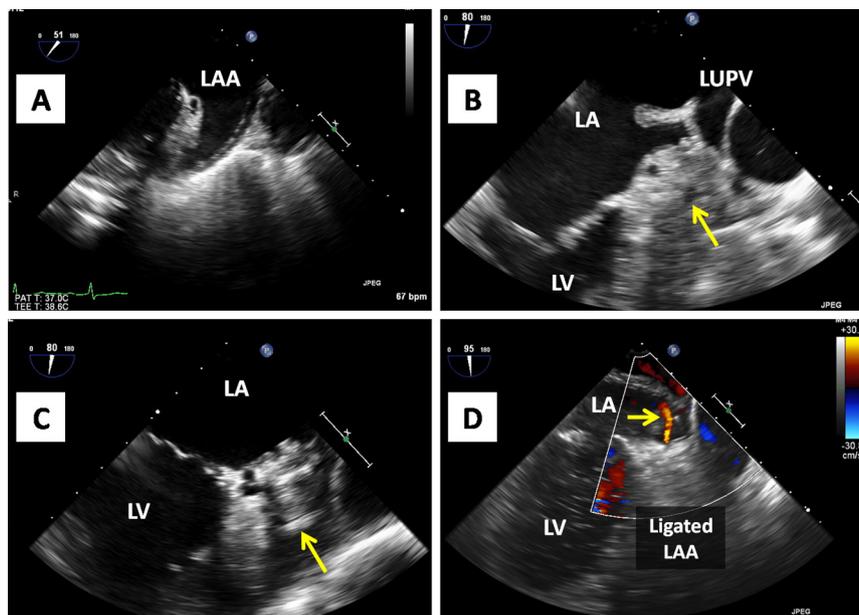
TEE assessment of LARIAT closure of the LAA. (A) Two-dimensional TEE appearance of the LAA before LARIAT closure. (B) Typical appearance of the LAA after LARIAT ligation. (C) Appearance of a ligated LAA in another patient. In this patient, the presence of a pericardial effusion outlines the ligated appendage (arrow). (D) After the LARIAT snare is deployed but before removal of the endocardial catheter from the LAA, a small degree of central leak (arrow) may be seen on color Doppler imaging. LA, Left atrium; LV, left ventricle; LUPV, left upper pulmonary vein.
